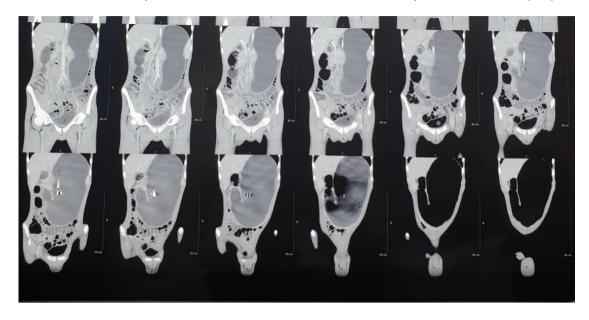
The Coronal section of contrast enhanced CT scan of abdomen and pelvis depicting grossly distended stomach and D1 D2 with twisting of mesentery at D3 and associated volvulus
